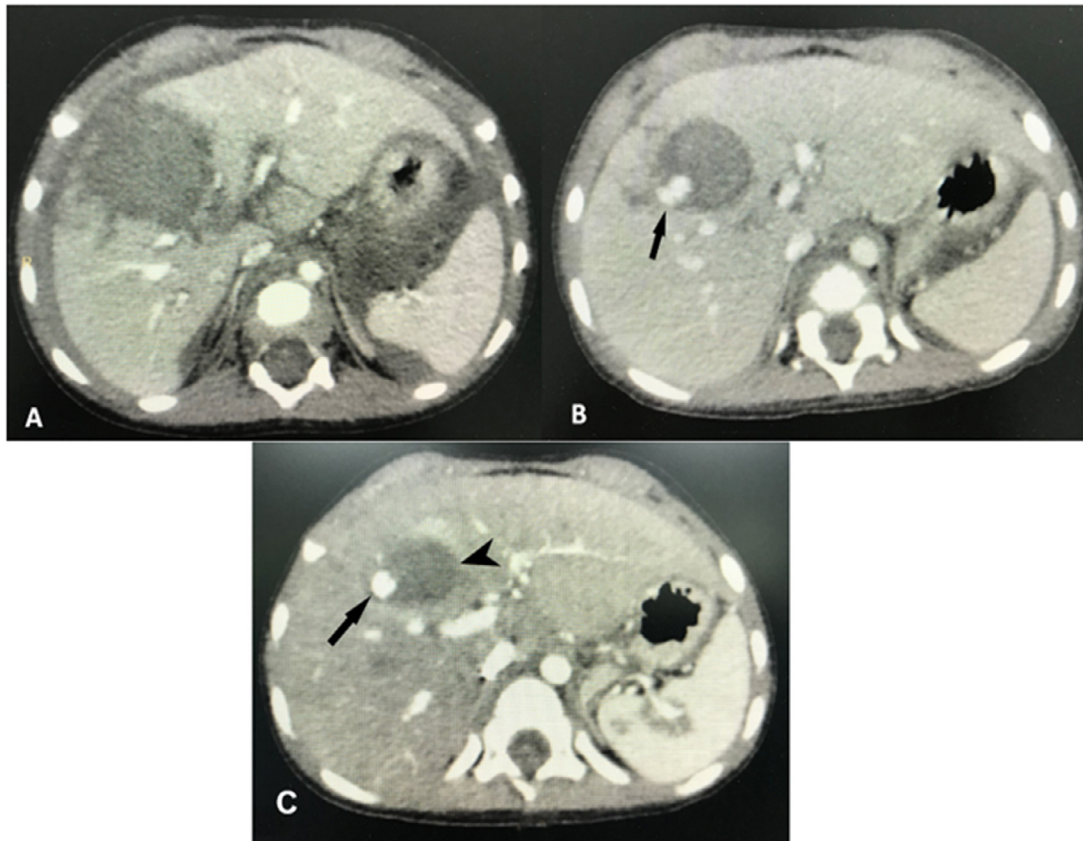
Image of liver injury on contrast-enhanced abdominal computed tomography imaging on the day of the injury and 15 and 36 days after the injury. (A) Liver parenchymal hematoma on computed tomography (CT) imaging at the time of admission (Day 1). (B) Liver parenchymal hematoma with internal pseudoaneurysm (arrow) on CT imaging 15 days after the injury. (C) The parenchymal hematoma was reduced in size (arrowhead) with a pseudoaneurysm mass (arrow) 36 days after the injury.
